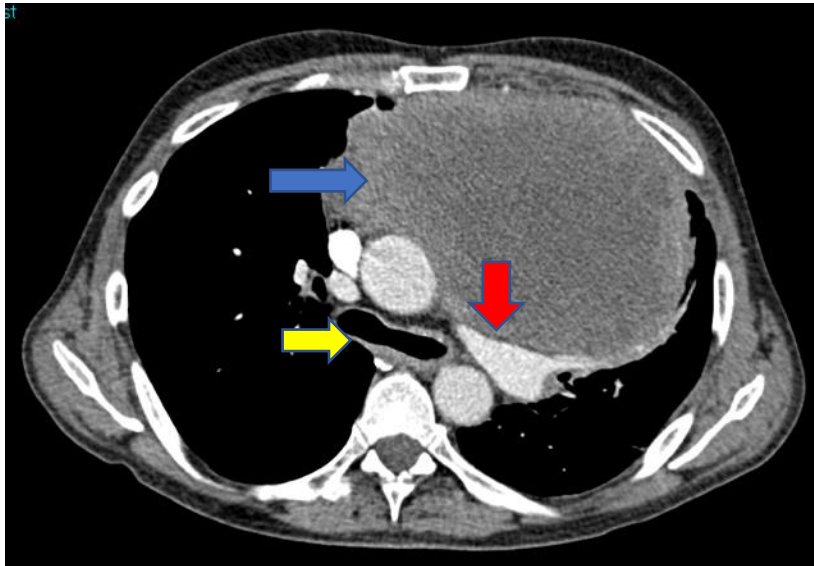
CT showing large germ cell tumour (blue arrow) compressing the carina (yellow arrow) and left main pulmonary artery (red arrow).
